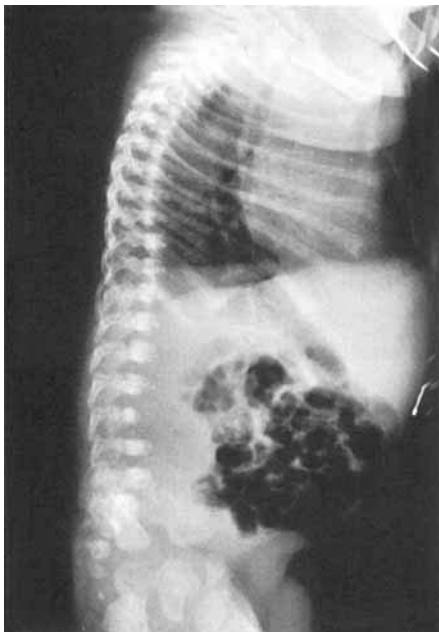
Lateral roentgenogram of the spine at birth with coronal clefting of the vertebral bodies and stippling along the spinal column.
